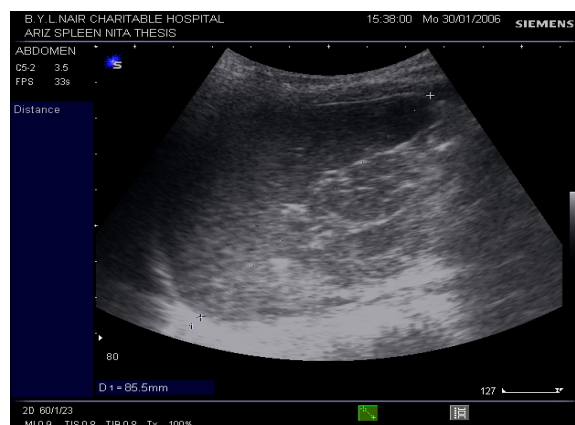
Gray Scale, B mode sonogram of the spleen showing normal dimensions of the spleen (splenic length) in a 9 yrs child.
